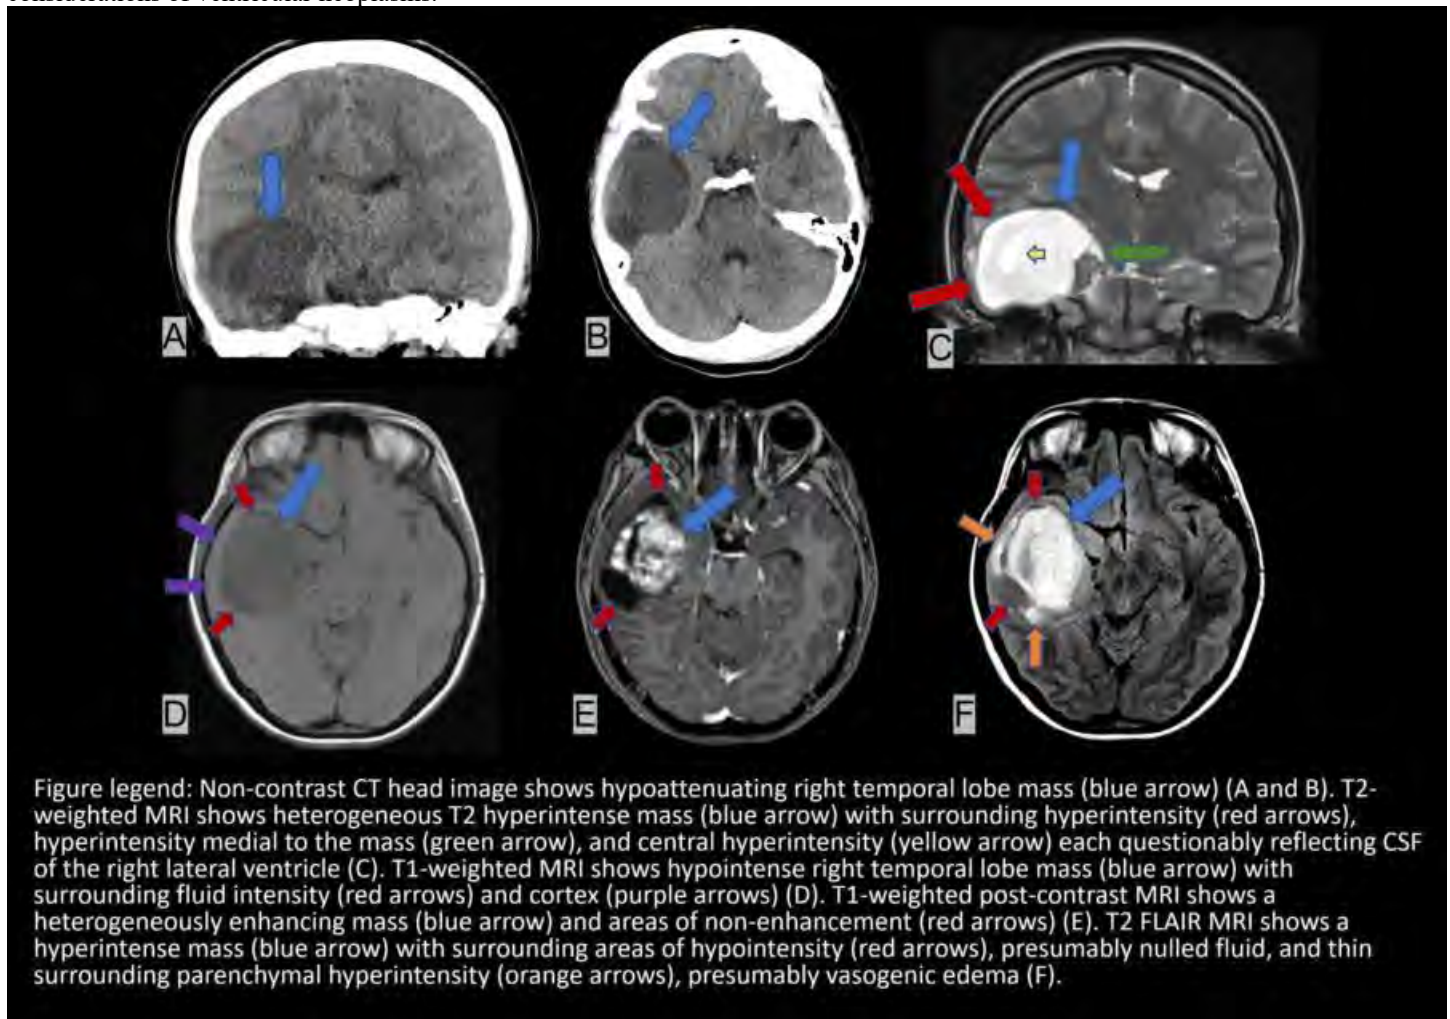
Figure legend: Non-contrast CT head image shows hypoattenuating right temporal lobe mass (blue arrow) (A and B). T2-weighted MRI shows heterogeneous T2 hyperintense mass (blue arrow) with surrounding hyperintensity (red arrows), hyperintensity medial to the mass (green arrow), and central hyperintensity (yellow arrow) each questionably reflecting CSF of the right lateral ventricle (C). T1-weighted MRI shows hypointense right temporal lobe mass (blue arrow) with surrounding fluid intensity (red arrows) and cortex (purple arrows) (D). T1-weighted post-contrast MRI shows a heterogeneously enhancing mass (blue arrow) and areas of non-enhancement (red arrows) (E). T2 FLAIR MRI shows a hyperintense mass (blue arrow) with surrounding areas of hypointensity (red arrows), presumably nulled fluid, and thin surrounding parenchymal hyperintensity (orange arrows), presumably vasogenic edema (F).
